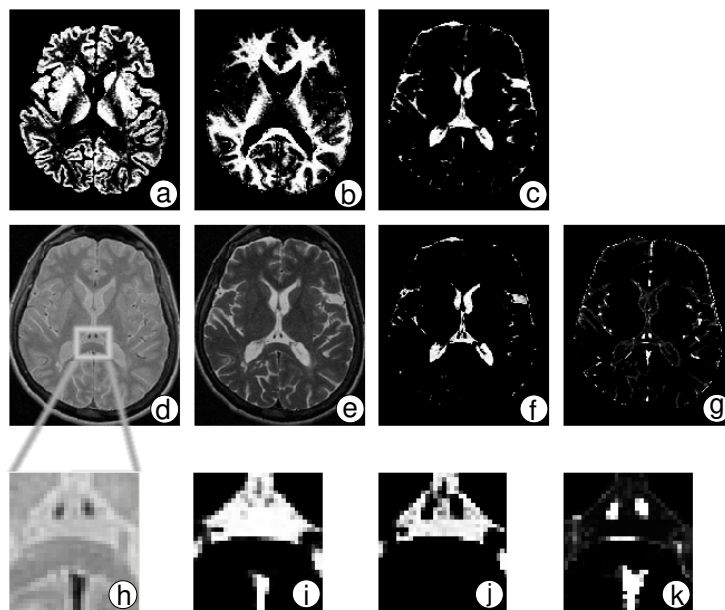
Final segmentation: grey matter (a), white matter (b), CSF without vessel class (c), T2 MRI (d), Proton Density MRI (e), CSF (f), other class including vessels (g). Zoom : Proton Density (h), CSF without vessel class (i), CSF (j), other class including vessels (k).
